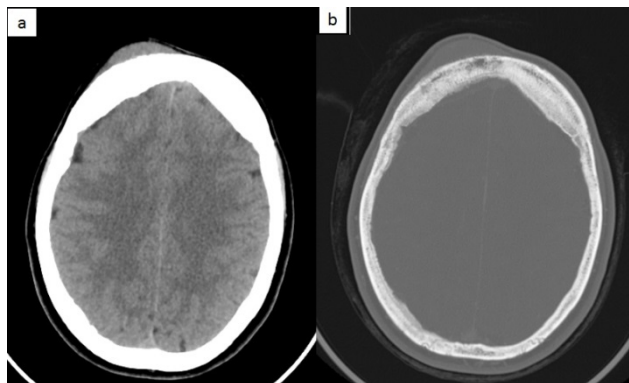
Brain CT scan suggestive of hyperostosis meningioma en plaque: multifocal dural enhancing thickening /masses mostly along the right cerebral hemisphere from the frontal to the parietal regions associated with hyperostosis of the skull infiltrating the dura and adjacent bone and soft tissue.
